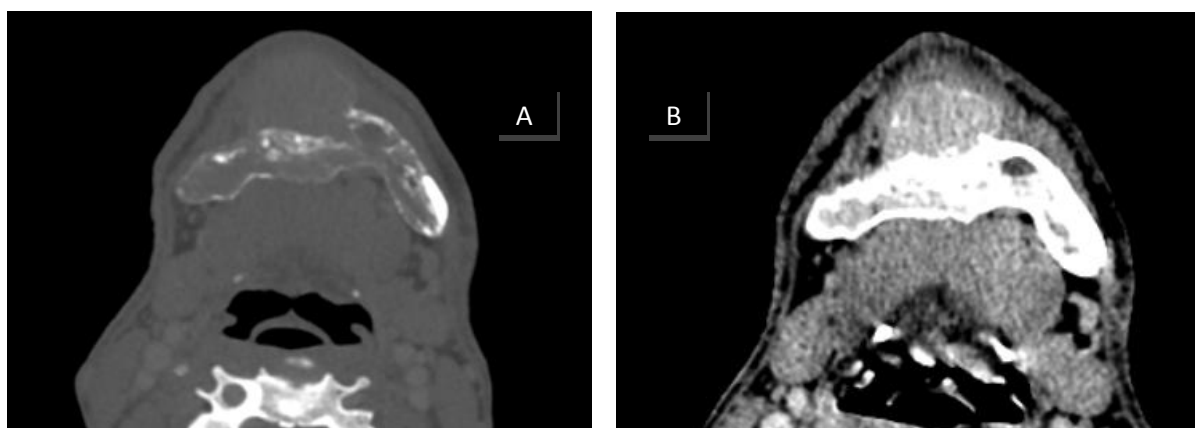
Contrast Enhanced CT scan in A) bone window, B) soft tissue window
